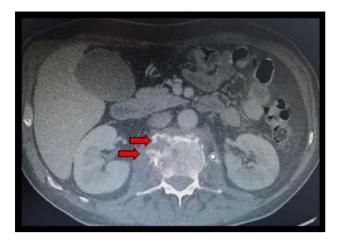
Axial computed tomography, bone window. Spondylodiscitis (red arrows).
